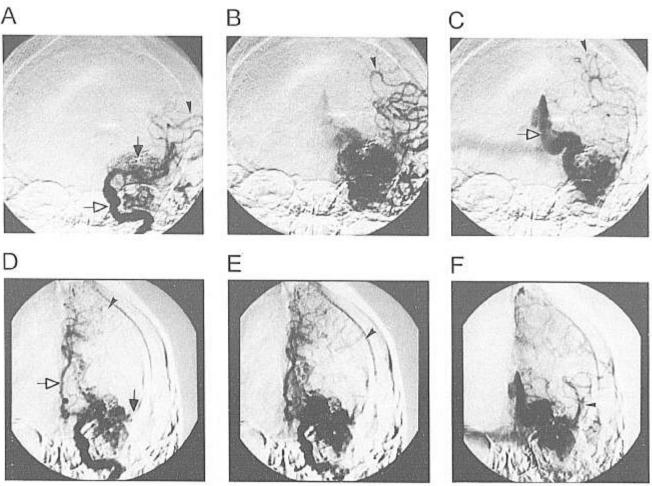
An example of how deliberate hypertension can be used as a temporizing measure to treat acute proximal occlusive ischemia. This 54-yr-old woman underwent glue embolization of a temporal arteriovenous malformation (AVM). (A-C) Anteriorposterior views of contrast injection demonstrate the passage of dye through the ipsilateral normal middle cerebral artery (MCA) and the AVM. (A) The open arrow indicates the internal carotid artery, just proximal to the origin of the MCA. The closed arrow indicates the nidus with n-butyl cyanoacrylate (NBCA) from a previous embolization. The arrowhead indicates normal filling of the distal MCA branches. (B) Several seconds later. The arrowhead indicates contrast moving distally out of the MCA territory. (C) The open arrow shows the draining vein, and the arrowhead indicates the borderzone of a normal MCA territory. After NBCA injection, reflux of glue around the catheter resulted in the tip becoming cemented to the vessel wall. Removal was attempted with gentle, intermittent traction. The patient complained of pain at one point, and there was a question of vascular rupture. The blood pressure was kept in the low to normal range, and the heparin was reversed with protamine. The patient was neurologically unchanged at this point. Shortly thereafter, profound hemiparesis and aphasia developed, and fluoroscopy demonstrated occlusion of the first (M1) portion of the MCA. Systemic blood pressure was increased 40-50% with phenylephrine, and the deficit improved dramatically. (D-F) Contrast injection during deliberate hypertension demonstrates how contrast now passes through the (previously unvisualized) ACA and, via pial-pial collaterals, retrograde into the ischemic MCA territory. (D) The open arrow shows contrast now filling the ipsilateral ACA, the closed arrow indicates the occluded MCA stem, and the arrowhead indicates contrast reaching the normally expected edge of the ACA borderzone. (E) Contrast is seen advancing into the MCA distribution retrogradely, finally filling the proximal MCA in F. Within an hour, the clot in the MCA spontaneously lysed and migrated distally, and antegrade filling of both the ACA and the MCA was observed (not shown). The patient's neurologic examination stabilized with very mild aphasia and hemiparesis. A small temporal infarct was visualized on postprocedure computed tomography at 24 h.
